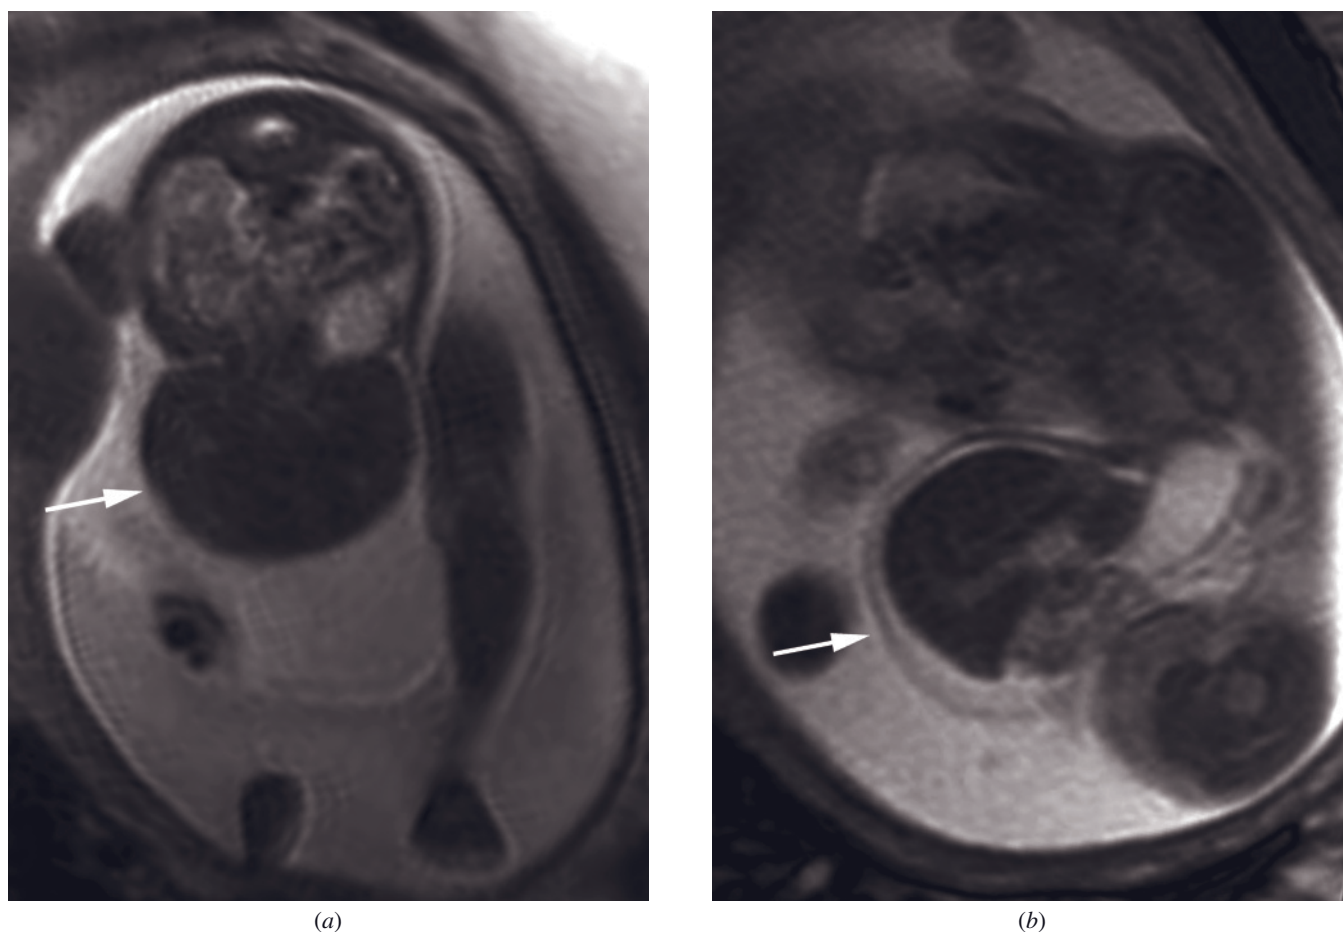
Omphalocele. T2-weighted ETSE images of a 25-week fetus obtained in the transverse and sagittal planes demonstrate a herniation of the anterior abdominal wall containing liver, stomach, and bowel (arrows). Note the covering membrane (a) and midline herniation, characteristic of omphalocele.
